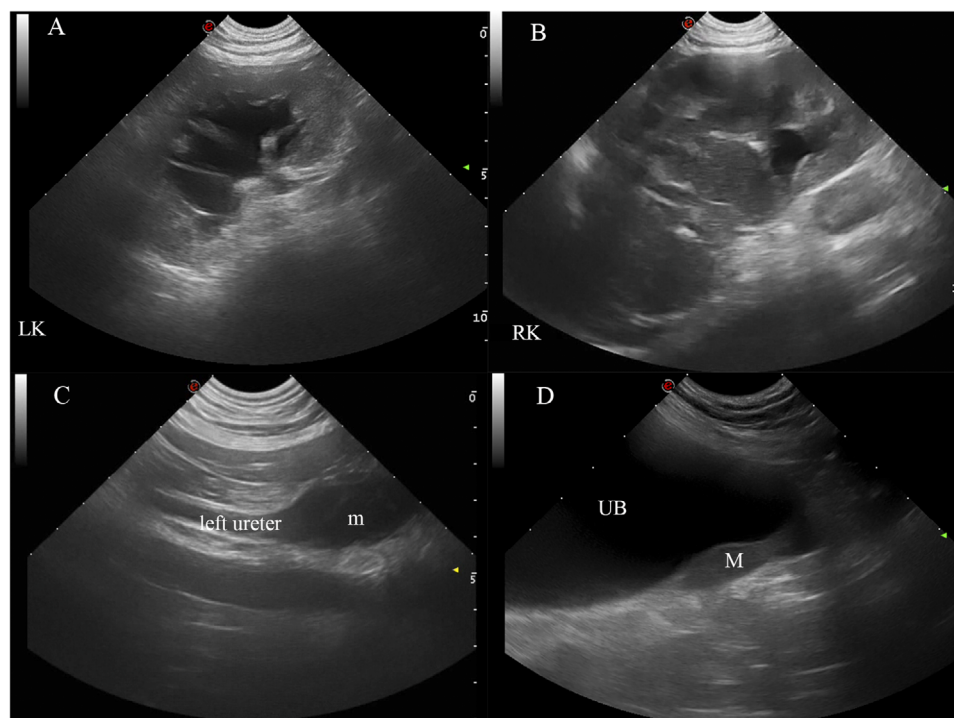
Ultrasonographic images of the left kidney showing severe hydronephrosis (A), enlarged unstructured right kidney with loss of corticomedullary distinction and heterogeneous echotexture (B), left ureter moderately dilated presenting a hypoechoic mass (C) and urinary bladder with a hypoechoic broad-based mass at the level of the trigone (D)
